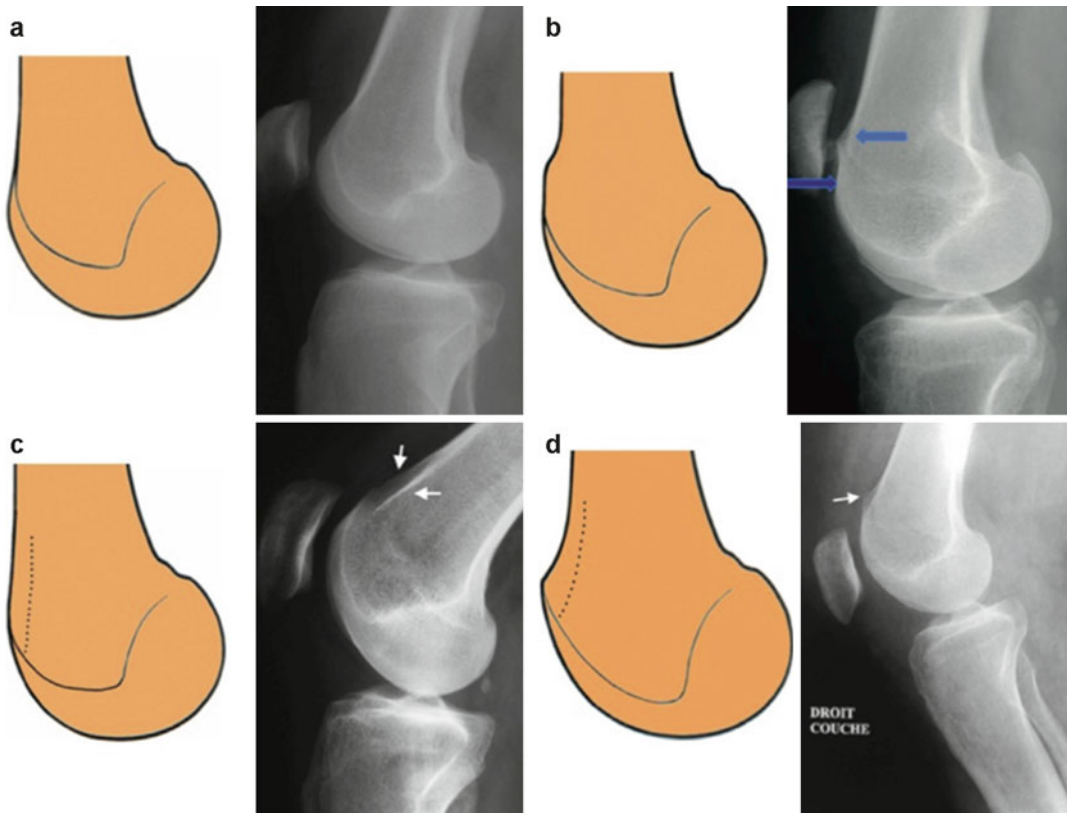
Dejour's classification of trochlear dysplasia. (a) Type A: Crossing sign but a normal morphology at CT scan. The trochlear angle is $>145^\circ$. (b) Type B: Crossing sign, supratrochlear spur and flat trochlea at CT scan. (c) Type C: Crossing sign and double contour. Medial facet is
